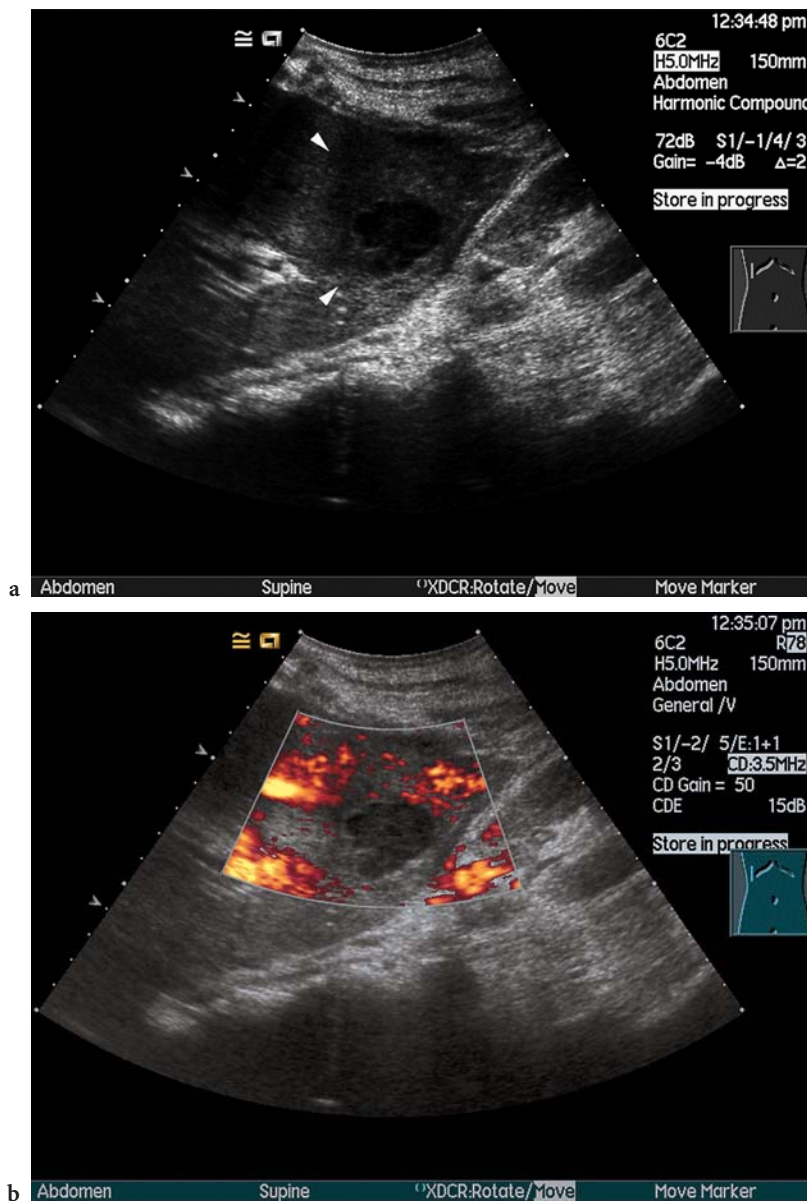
a This liver abscess formed by extension from an aggressive cholecystitis is seen as a region of slightly reduced reflectivity (arrowheads) with a small central cavity that is multiloculated. b The inflamed tissue is markedly hyperaemic on colour Doppler
